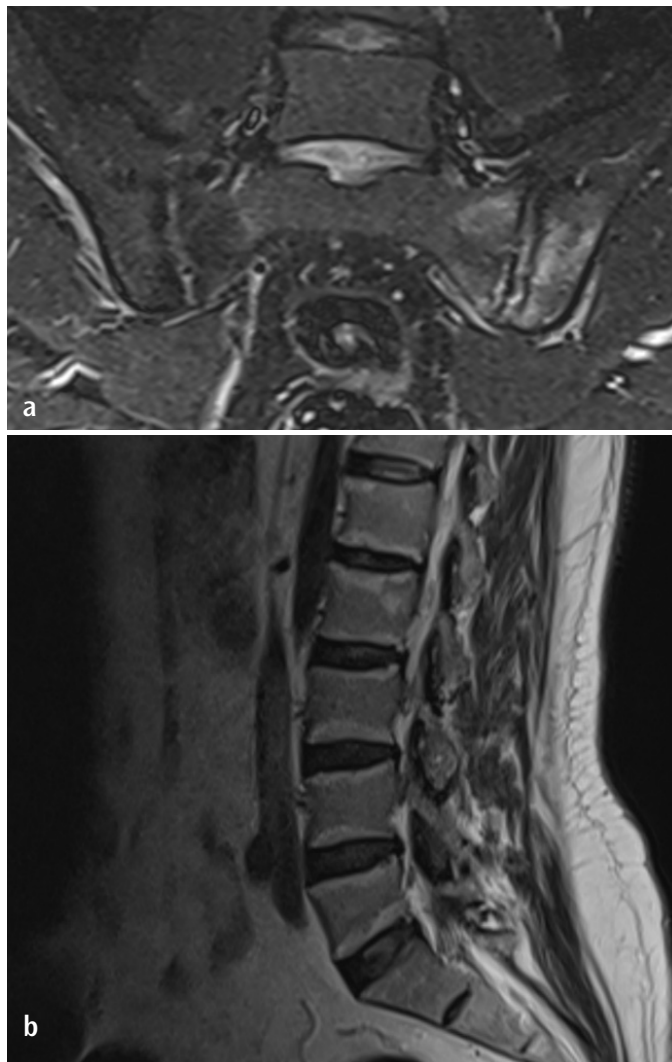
a) Sacroiliac MRI: Areas with millimetric cystic signal characteristics and slight irregularities were observed on the bone surfaces forming the sacroiliac joint on the right. On the left side, in addition to similar changes, signal changes that may be compatible with bone marrow edema and inflammation were observed in a T2A series of the iliac and sacral bone faces overlooking the sacroiliac joint. The findings were in favor of active sacroiliitis on the left. b) Thoracolumbar MRI: T1 and T2 are compatible with fatty degeneration in the lower thoracic vertebra and lumbar vertebra, and edema in the lumbar vertebra corpus appears suspicious for spondylodiscitis
